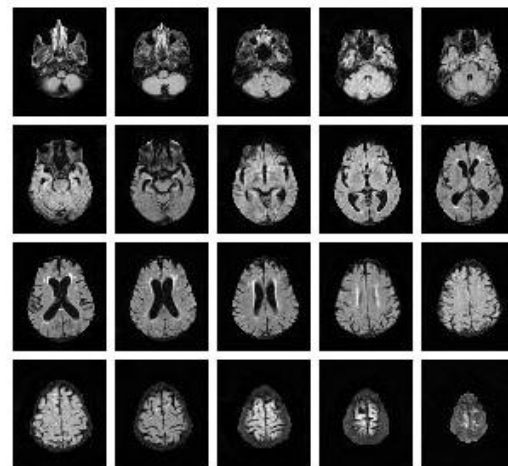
Axial MRI scans of a 35 year old female healthy subject (Sample 4)
